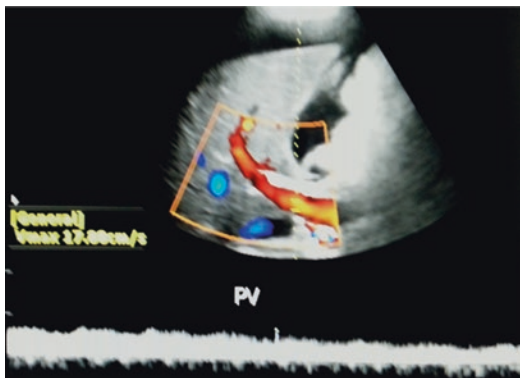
Portal vein colour flow and Doppler waveform in liver cirrhosis
